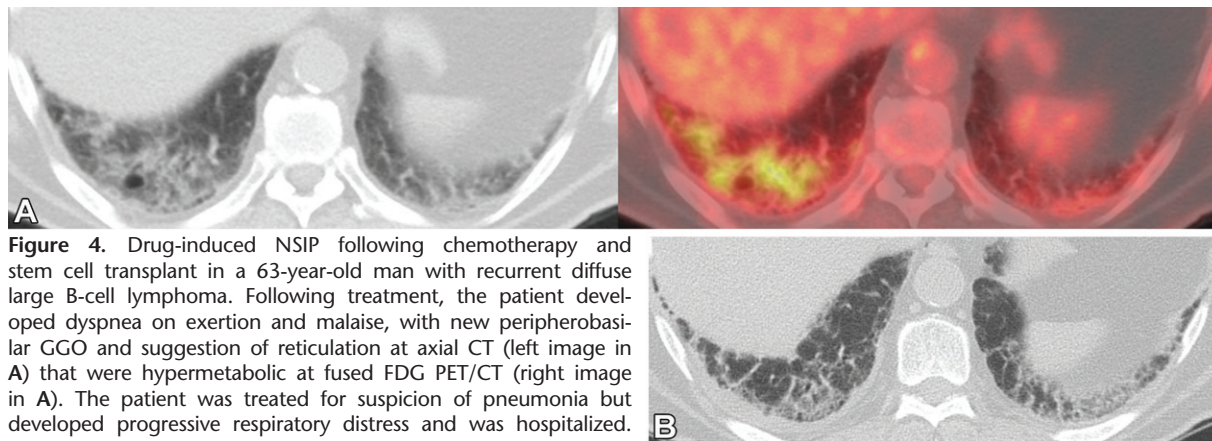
Drug-induced NSIP following chemotherapy and stem cell transplant in a 63-year-old man with recurrent diffuse large B-cell lymphoma. Following treatment, the patient developed dyspnea on exertion and malaise, with new peripherobasilar GGO and suggestion of reticulation at axial CT (left image in A) that were hypermetabolic at fused FDG PET/CT (right image in A). The patient was treated for suspicion of pneumonia but developed progressive respiratory distress and was hospitalized. (B) Transaxial chest CT image obtained at the time of hospitalization shows peripherobasilar reticulation with associated patchy GGO, most consistent with NSIP pattern pneumonitis that is probably secondary to gemcitabine and/or carmustine chemotherapy. Following steroid therapy for pneumonitis, the patient improved clinically, and follow-up FDG PET/CT (not shown) demonstrated decreased FDG uptake associated with bibasilar reticulation and patchy GGO.
